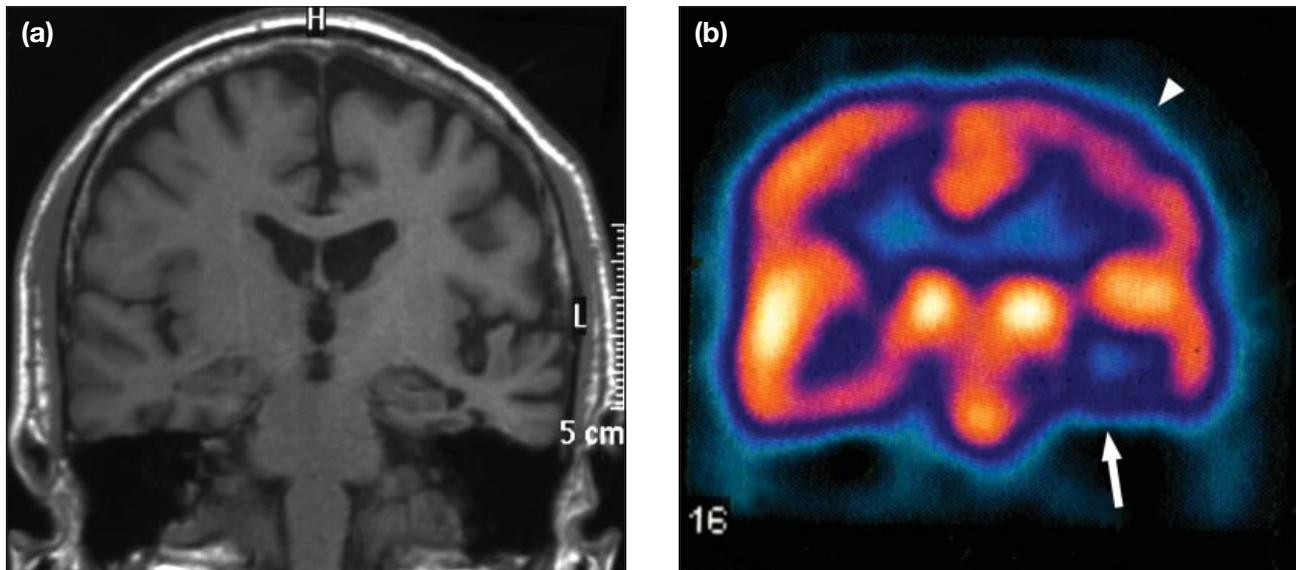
Imaging for patient 1. (a) Coronal T1-weighted magnetic resonance image showing unilateral left frontotemporal atrophy; and (b) coronal single photon emission computed tomography image showing left frontal lobe (arrowhead) and left temporal lobe (arrow) hypoperfusion.
